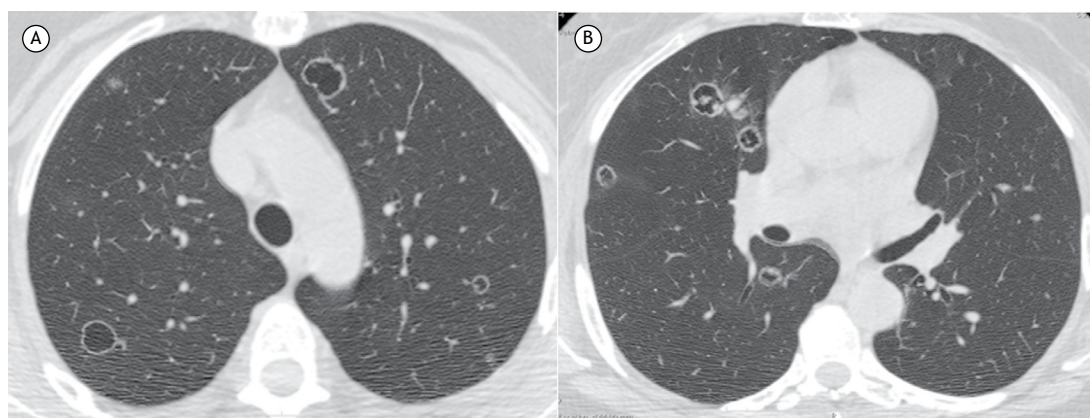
CT scans with lung window settings at the level of the upper lobes (in A) and lung bases (in B) showing multiple nodules of varying sizes, many of them cavitated, predominantly with peripheral distribution. Note solid content inside some of the nodules.
